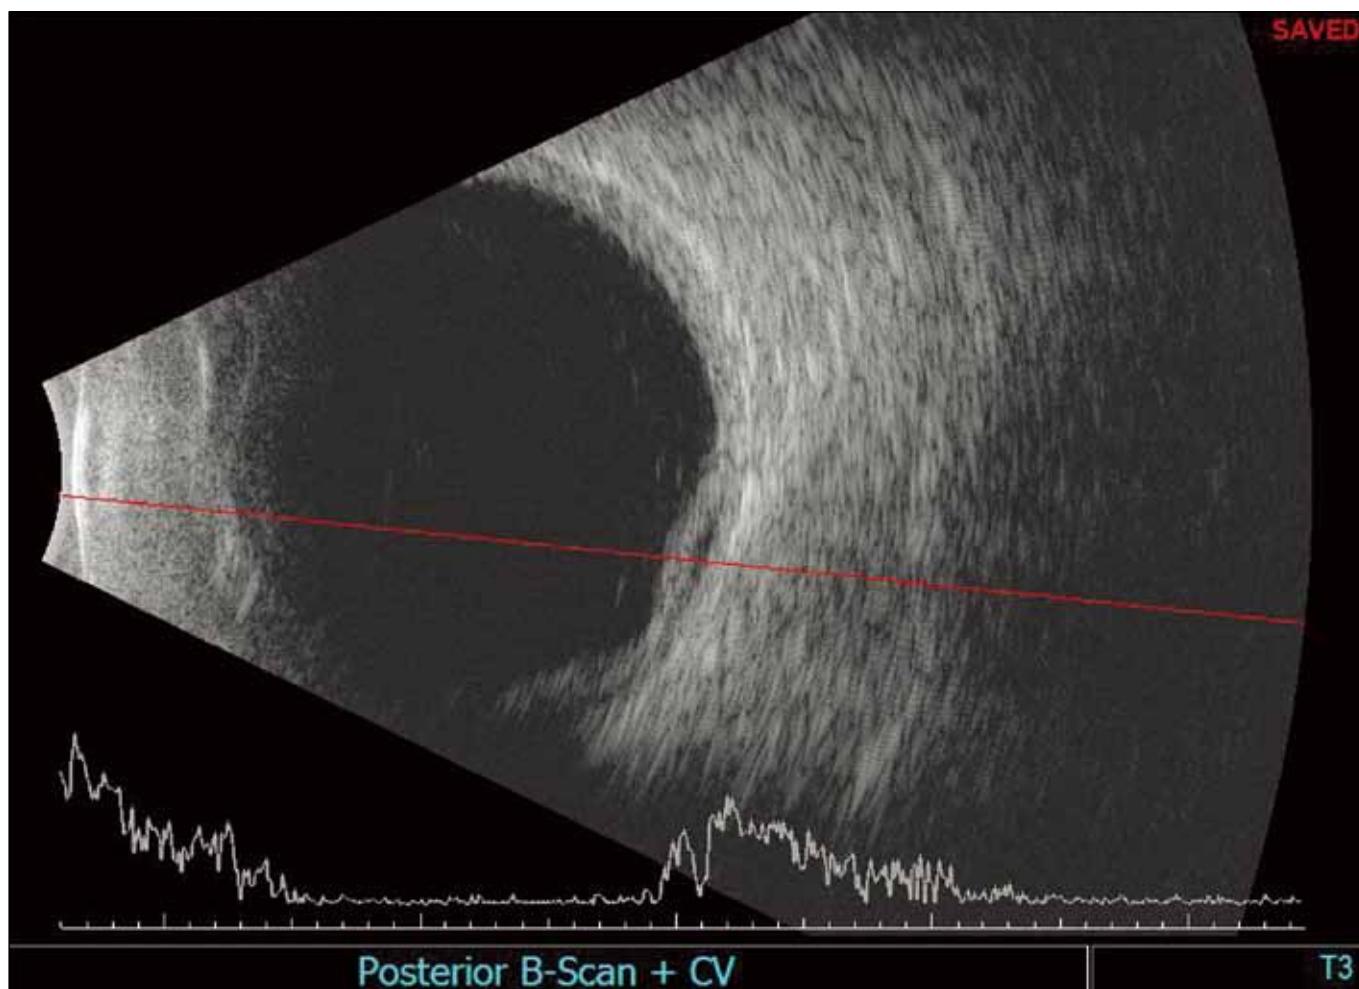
B-scan ultrasound showing choroidal effusion.
